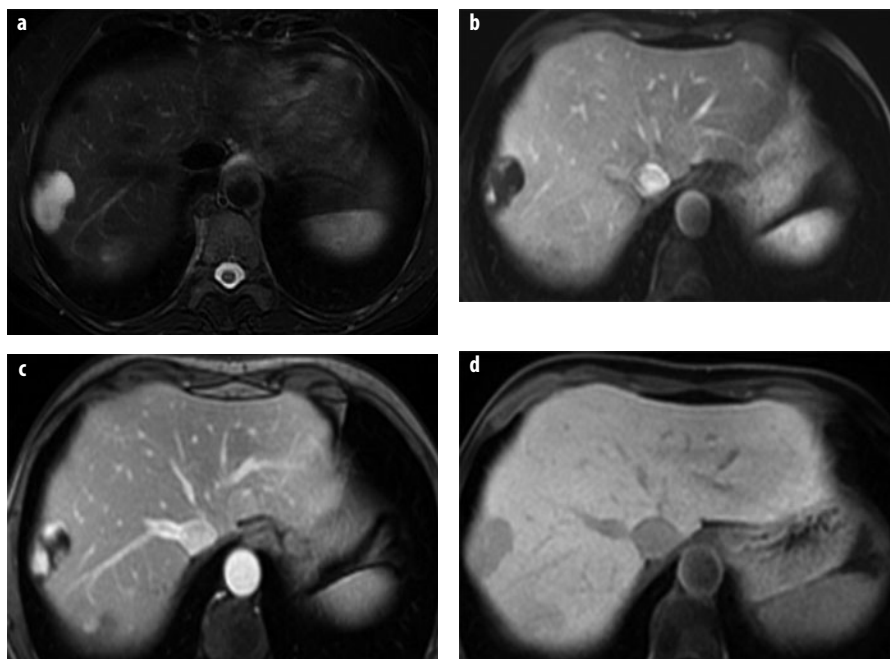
a-d. Hemangioma type 3: gadoxetic acid. a T2-weighted TSE image shows a large, lobulated lesion of very high signal intensity. b-d Dynamic gadoxetic-acid-enhanced imaging shows peripheral nodular enhancement in the b arterial and c venous phases. In the d hepatobiliary phase, there is marked lesion hypointensity due to washout in the lesion and enhancement of surrounding liver parenchyma
